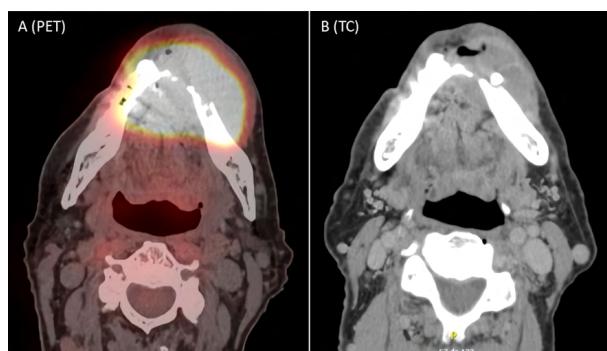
PET-scan portraying expansive and infiltrative lesion, heterogeneous enhancement in left alveolar edge mandible involving the mentonian symphysis and bilateral parasympysis with maximum SUV of 44.77.
